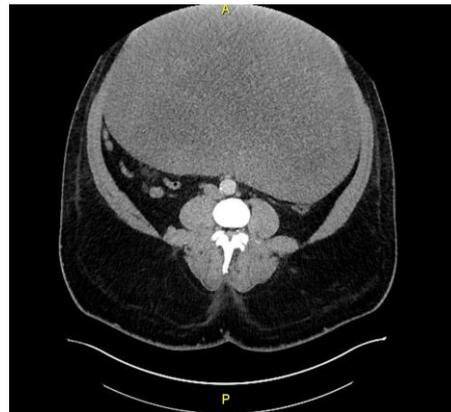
CT imaging (axial) demonstrating the association of the tumor with the aorta and inferior vena cava.
